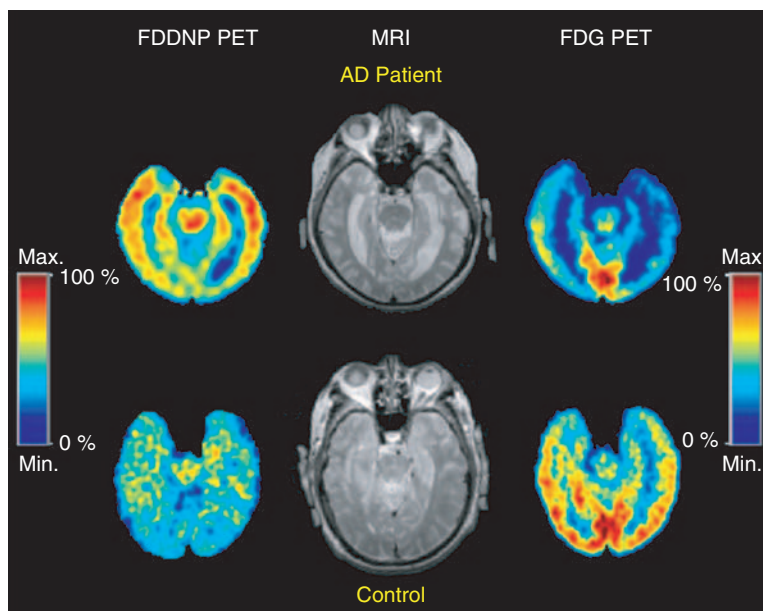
FDDNP PET, MRI, and FDG PET images of an AD and control normal subjects. The FDDNP PET of the Alzheimer's patients (AD; upper scans) shows increased signal (red) in temporal memory regions compared with the control (below). The FDDNP chemical marker is attracted to the plaques and tangles in the brain, which is the physical evidence of Alzheimer's disease in the living patient. The FDG PET shows glucose metabolism indicating how well the neurons are firing. In the Alzheimer's case, the FDG PET shows decreased neuronal activity in the brain regions where FDDNP shows increased activity (i.e., high concentrations of plaques and tangles). The MRI scans show brain structure but no signal for plaques and tangles. Reproduced with permission from Shoghi-Jadid K *et al.* (2002) Localization of neurofibrillary tangles and beta-amyloid plaques in the brains of living patients with Alzheimer's disease. *American Journal of Geriatric Psychiatry* 10(1): 24–35.
